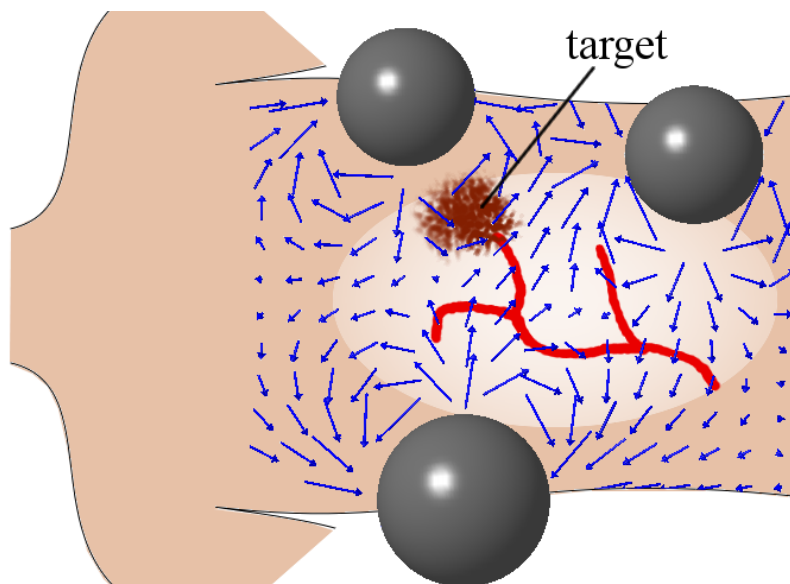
In DFN, ferromagnetic cores positioned around the patient in an MRI scanner generate gradients (arrows) for navigation towards a target.
